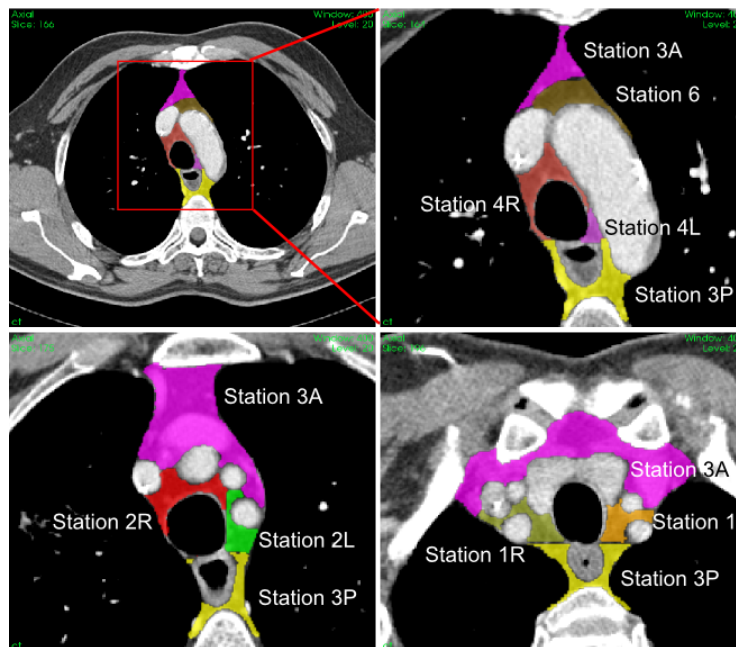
Examples of mediastinal stations delineated on a thoracic CT.
